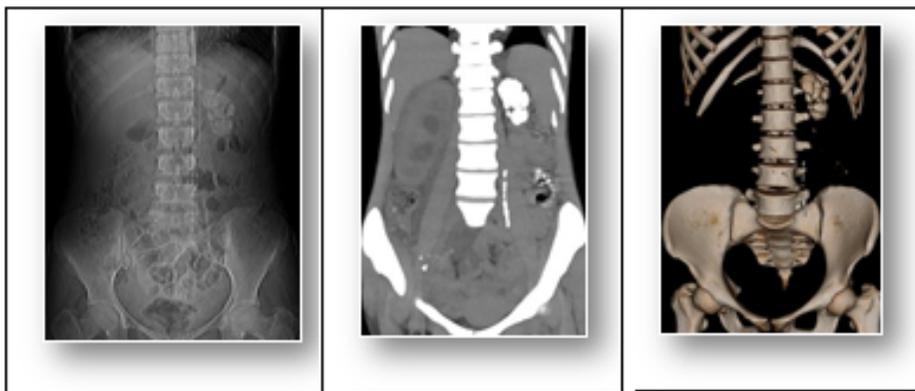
24 & 25: Scout film (Topogram), MIP and 3D-Volume Rendered images from a Plain CT study, showing Lobar calcifications in the left kidney with linear left ureteric calcification in a patient with Renal Koch's.
